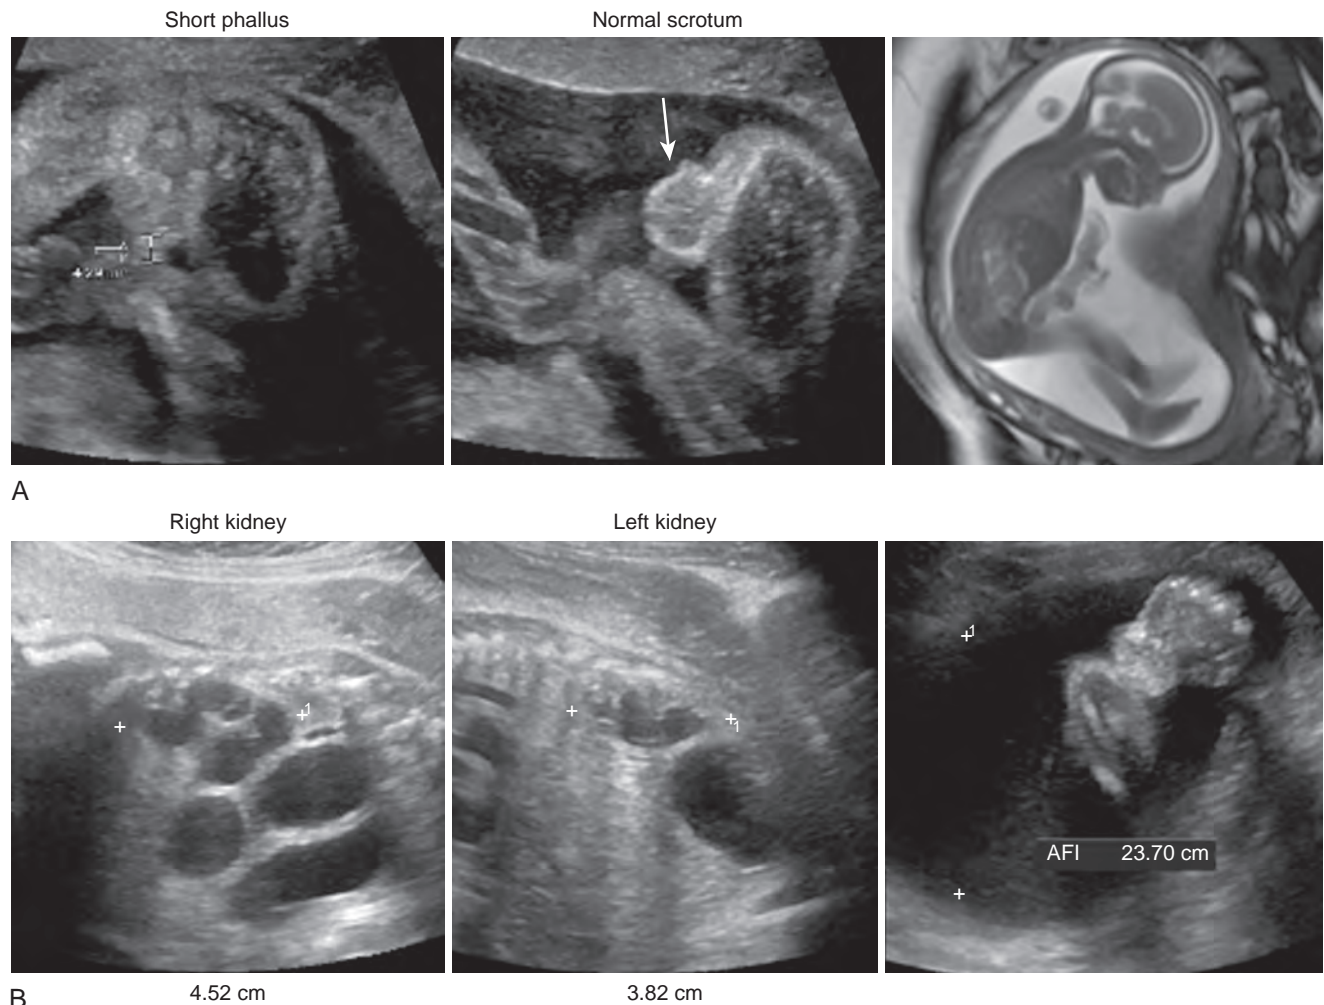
A, Prenatal sonography and magnetic resonance image of male fetus with classic bladder exstrophy. The kidneys were normal, and no hydroureter was seen, but the cord inserted low into the abdomen, the bladder was not visualized in pelvic views, and the phallus was short. B, Prenatal sonogram of male fetus with prune-belly syndrome demonstrating the presence of a high amniotic fluid index (AFI). Although prune-belly syndrome and posterior urethral valve share sonographic features, such as hydronephrosis and hydroureter, this case did not demonstrate a thickened bladder wall and distinct “keyhole” sign, which are typical of posterior urethral valve. Also, the testes were not seen in the scrotum, which is another prenatal clue that the diagnosis was prune-belly syndrome.
